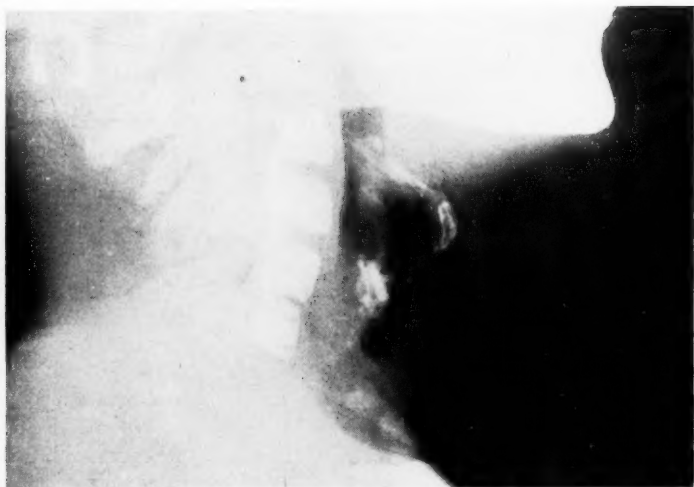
X-ray of larynx at present time. Note obliquity of hyoid due to downward pull on muscles of neck by scar, also high degree of calcification and restricted lumen.
